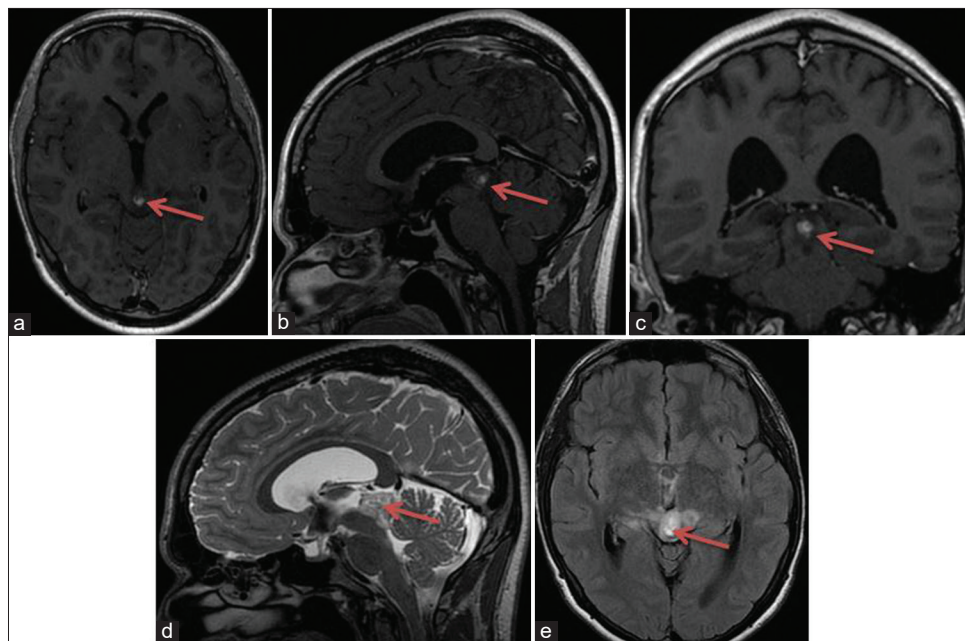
MRI scans (pre-operative) showing tumor location and radiological anatomy of a space-occupying lesion with partially and heterogeneous contrast enhancement in the pineal region (a,b,c). FLAIR and TW2 hyperintensity in and around the pineal region (d, e).
